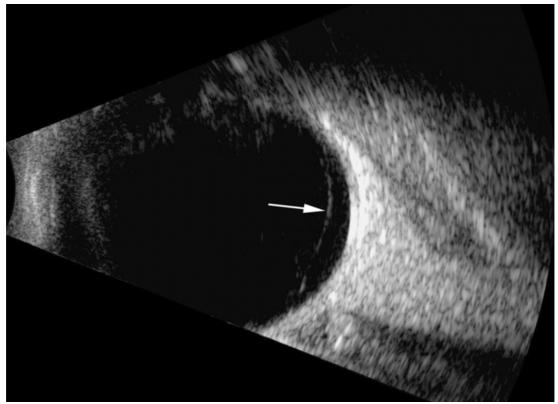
10MHz ultrasound B-scan of vitreous demonstrating PVD; The arrow indicates the detached PVC (From Sebag J, Silverman RH, Coleman DJ: To see the invisible - the quest of imaging the vitreous. In Vitreous – in Health and Disease [J. Sebag, ed]¹).
